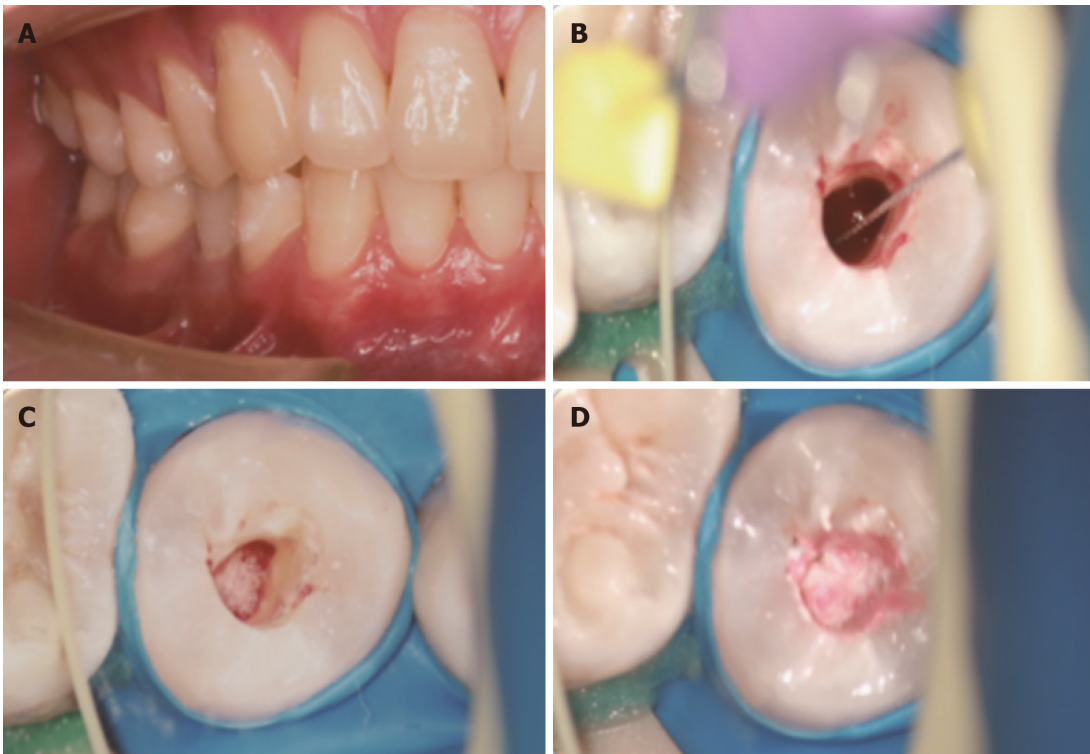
First treatment visit. A: Preoperative view; B: A preoperative periapical radiograph; C: Pus could be seen in the root canal; D: Triple antibiotic paste was used to seal the root canal.
